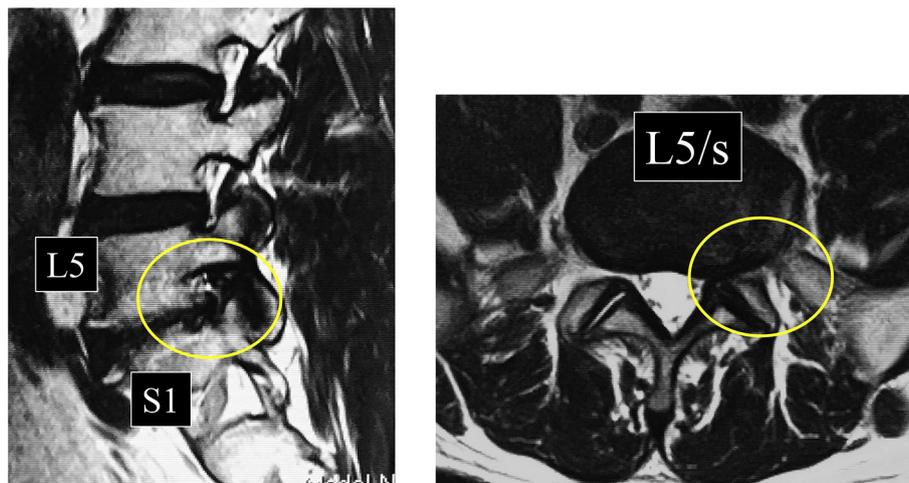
demonstrates the L5-s foraminal stenosis with herniated nucleus pulposus (HNP) before surgery. This case was 75 y.o. female. Due to the slight scoliosis, the left intervertebral foramen becomes stenotic. Also, far lateral HNP at the left L5-s is observed. Thus, the left L5 nerve root was impinged by both of osseous stenosis and HNP. Outside-in technique was selected for the case. The superior articular process of S1 and sacral alar was partially removed (Fig. 8), leading to the foraminal widening. The laterally migrated HNP was, then, removed. Following the osseous decompression and HNP removal, L5 nerve root can be decompressed. On the CT scans taken before and after the surgery, the area of the foraminoplasty, indicating the foraminal widening, is clearly seen in Fig. 8. Immediately after the surgery, her leg pain and numbness improved.
